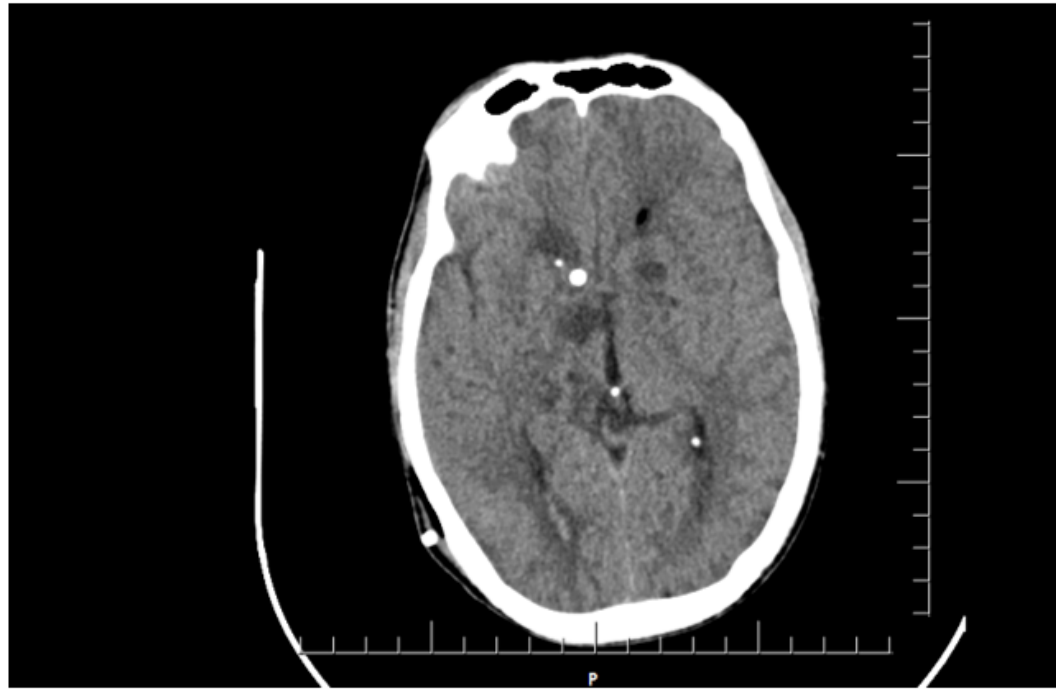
CT Brain F/U no hydrocephalus after EVD with RT Thalamic and LT internal capsule infarction.
